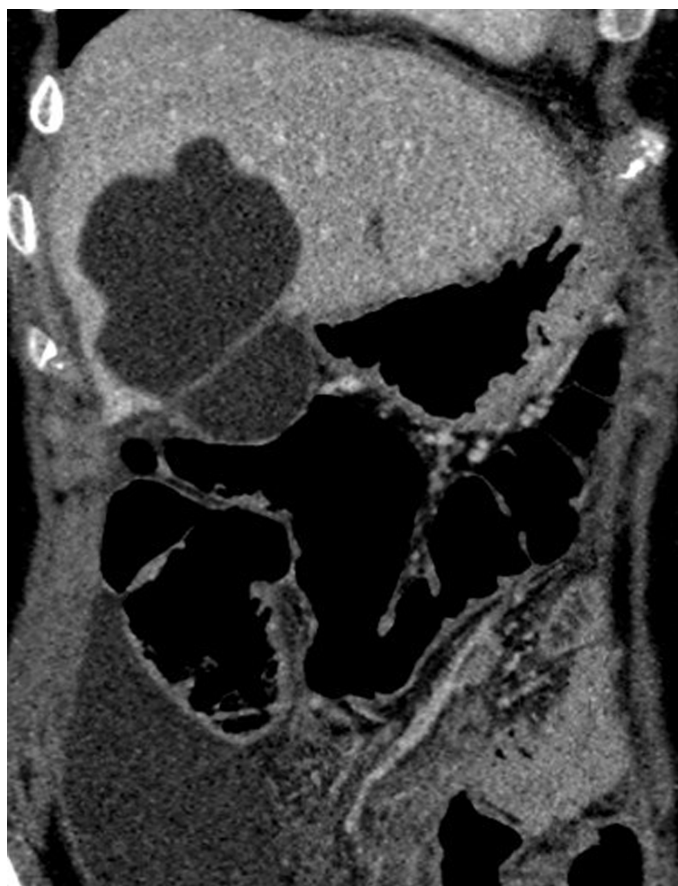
Coronal reformatted images of the venous phase of computed tomography shows perforated hydatid cyst located in segment V of the liver. This image also shows fluid collection in the right paracolic area.
